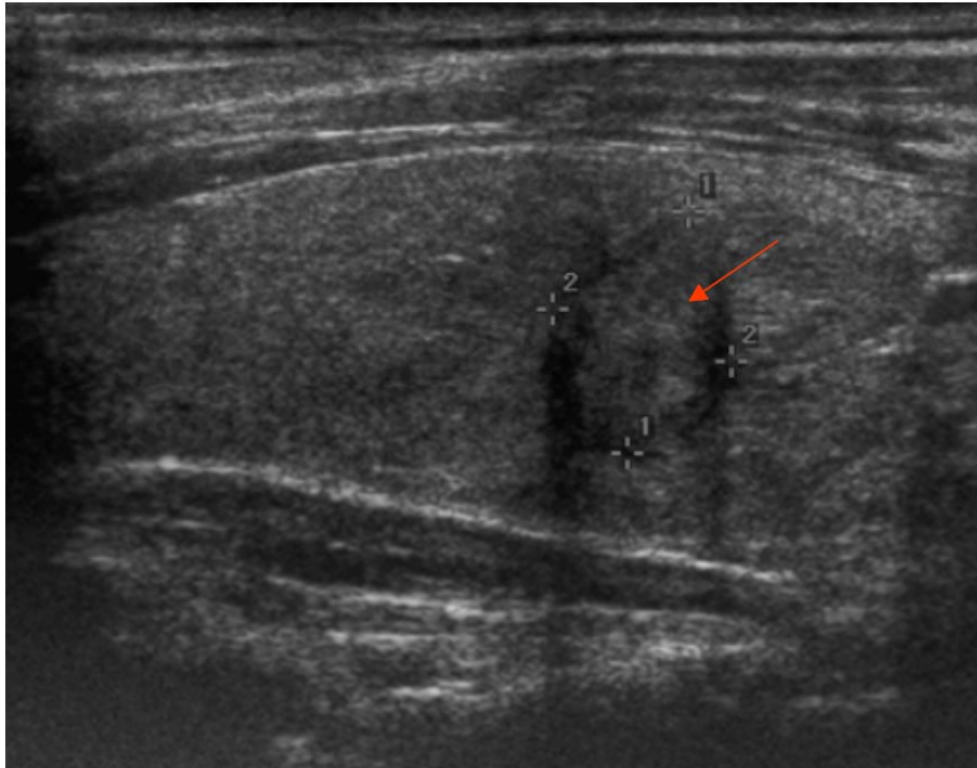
Ultrasound of thyroid showing nodule in left lobe with a nearly complete halo.
